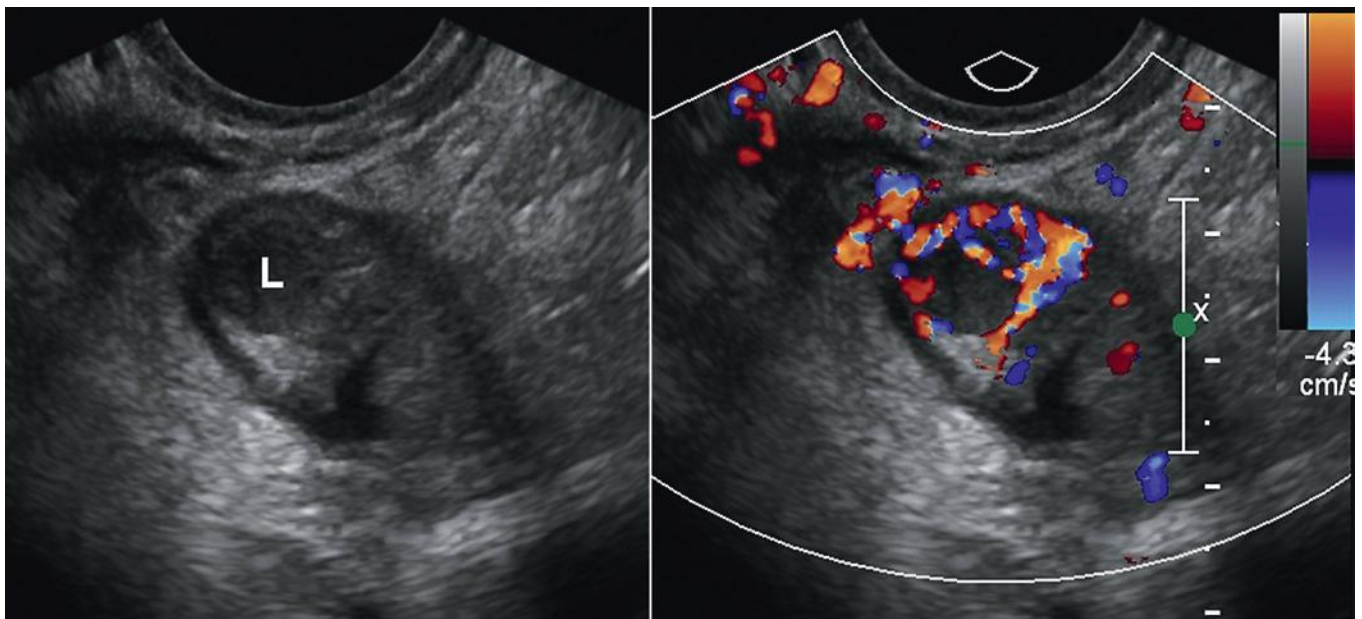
Acute salpingitis: Split screen image of the fallopian tube in cross section on gray-scale (*left*) and color Doppler (*right*). The wall of the fallopian tube is thick and hyperemic with a small amount of complex fluid in the lumen (L). The surrounding fat is echogenic and vascular consistent with inflammation.
